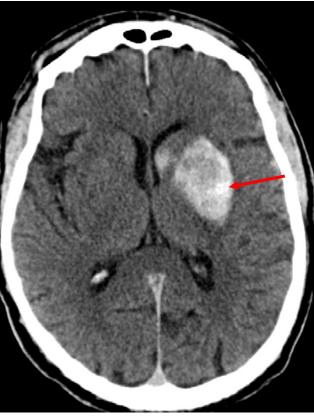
Haemorrhagic infarct (arrow) as seen on CT.
